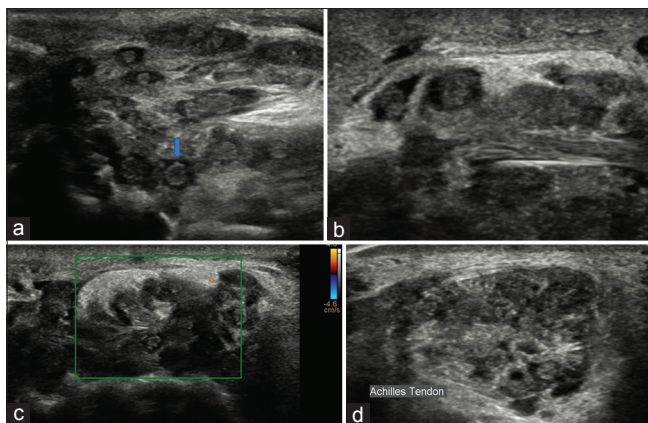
(a) High-resolution sonography image and (b) magnified image showing multiple clustered lesions, showing hypoechoic thick-walled lesions containing small, hyperechoic foci. No internal movement was seen. (c) On Doppler, there was no significant vascularity. (d) Multiple nodules were also seen in Achilles tendon.
